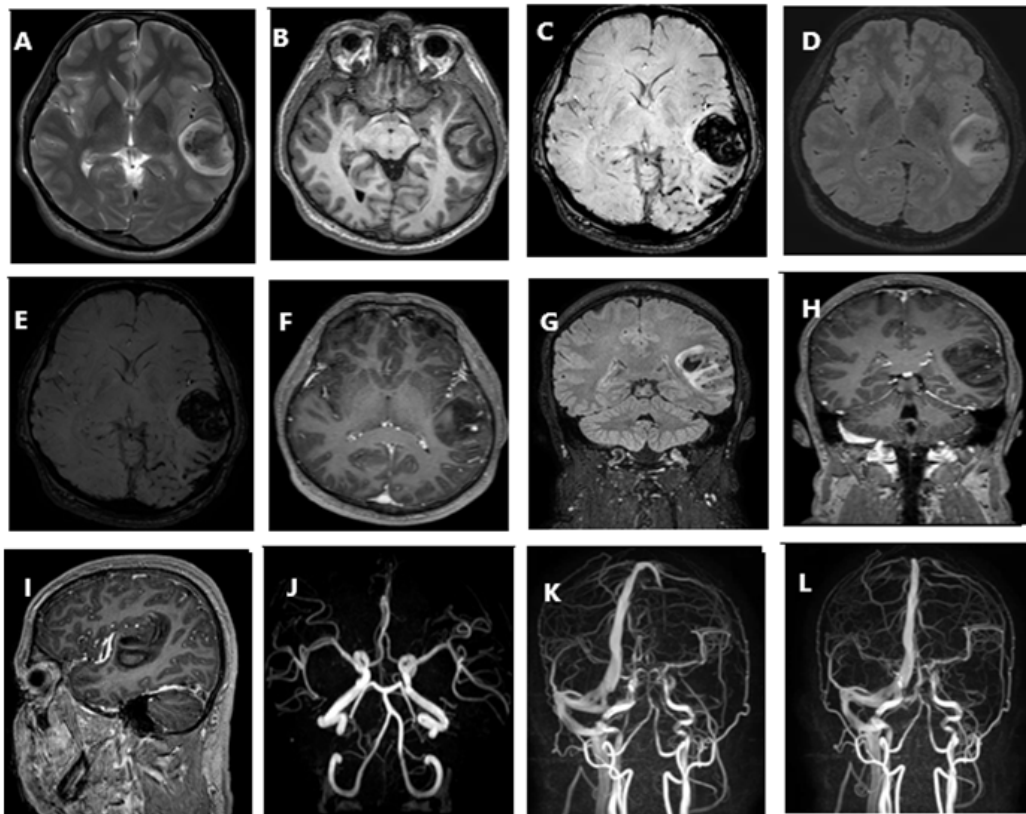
Multiplanar MRI of the brain with MRA MRV reconstruction with contrast injection was done and showed evidence of left temporoparietal cortical and deep sub cortical altered signal intensity lesion of acute/subacute blood intensity measuring about 31 x 56 x 40 mm, the parenchymal brain haematoma is surrounding by mild soft tissue oedema with mild mass effect to the related structure with minimal pressure effect at the brain ventricular system with no significant midline shift, no definite underlying pathological lesion could be seen, picture highly suggestive of lobar venous parenchyma brain haemorrhage Figure 2 (A-H). Nonvisualization of the left sigmoid and transverse sinus due to thrombosis, other dural venous sinuses including the superior sagittal, straight and right transverse sinus appear normal Figure 2 (I-L).
